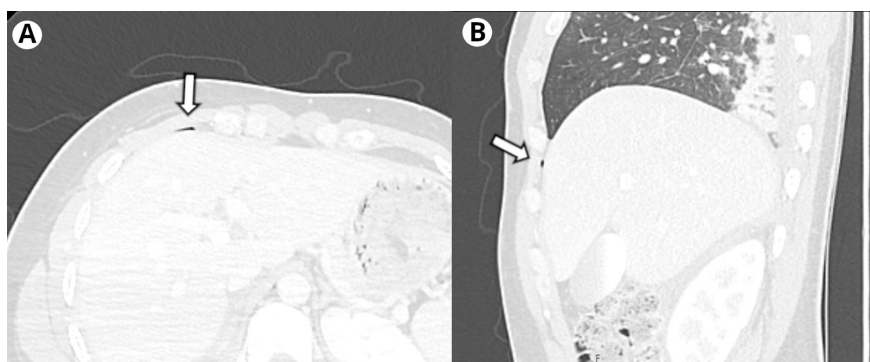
Computed tomography reconstructions in the lung window in the axial (3A) and sagittal (3B) views, zoomed in on the small pocket of air (arrow).
